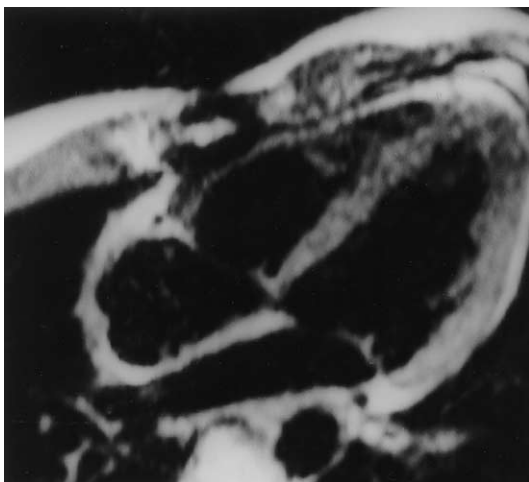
Magnetic resonance imaging of the heart 6 months after the operation. Spin echo magnetic resonance in longitudinal four-chamber view; there is no evidence of tumor mass.
